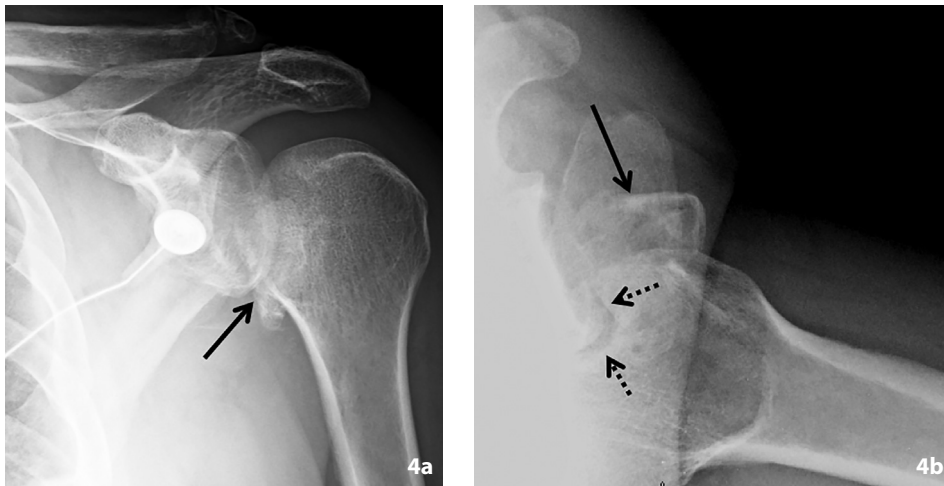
The “veil of obscuration” radiographic sign. (a) AP internal rotation radiograph of the left shoulder shows a displaced comminuted lesser tuberosity fracture (solid arrow) creating the “veil of obscuration” radiographic sign. (b) Axillary radiograph of the same shoulder demonstrates the displaced fracture of the lesser tuberosity (solid arrow). Also note posterior dislocation of the humeral head in relation to the glenoid with large reverse Hill-Sachs lesion at the anteromedial aspect of the humeral head (dashed arrows).
